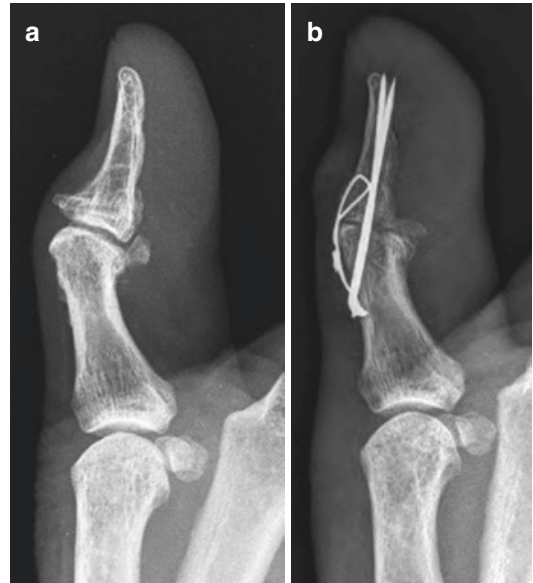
Radiographs showing arthrodesis (b) with tension band wiring in a patient with degenerative arthritis of interphalangeal joint of the thumb (a)
